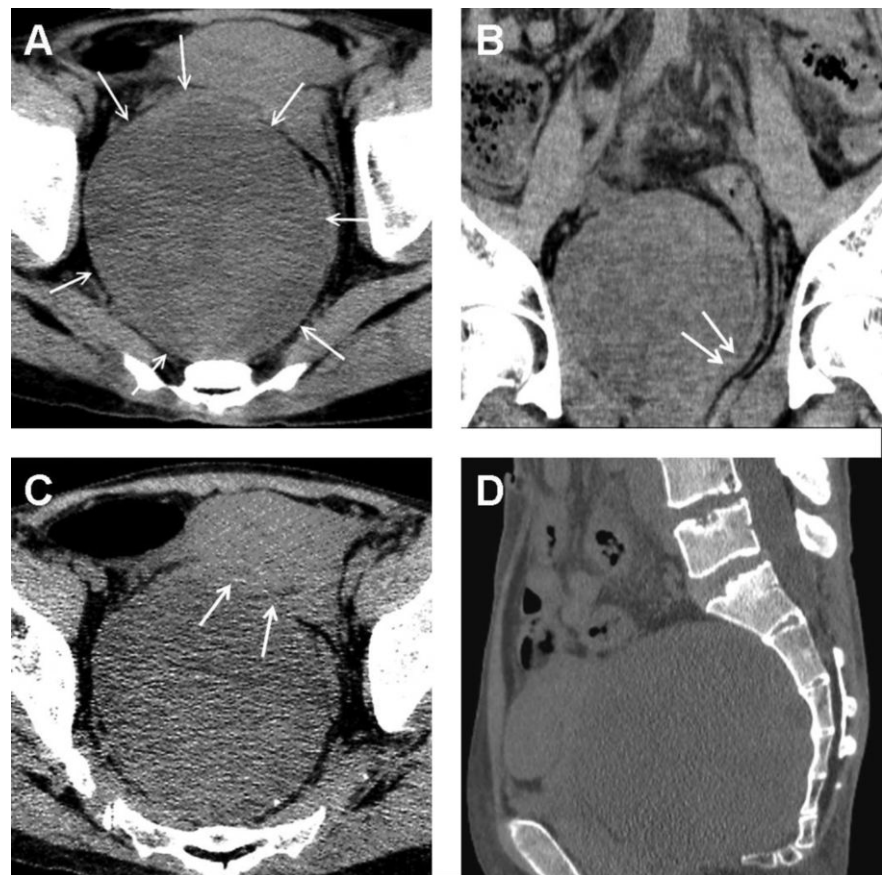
A) Non-enhanced computed tomography demonstrates an 11 cm well-demarcated, slightly heterogeneous, and round soft-tissue presacral mass (arrows) without nearby fat stranding; B) and C) the fat planes between the mass and the rectum (arrows in B) as well as the uterus (arrows in C) are obscure; D) sagittal view in bone window shows that the sacrum is intact.
